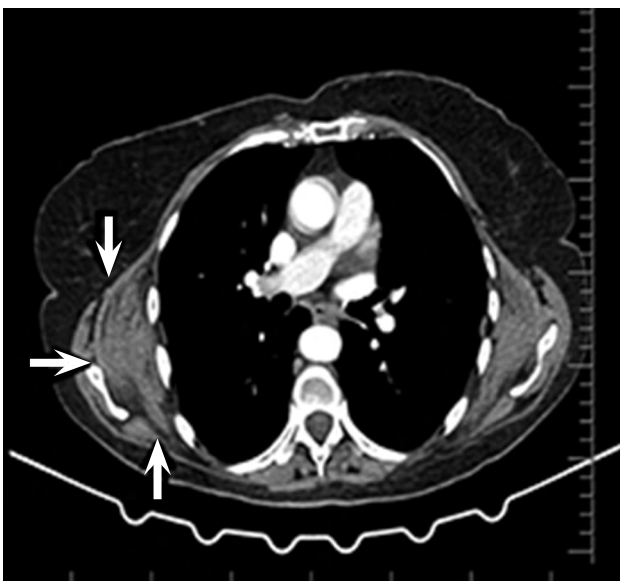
Thorax computed tomography.
